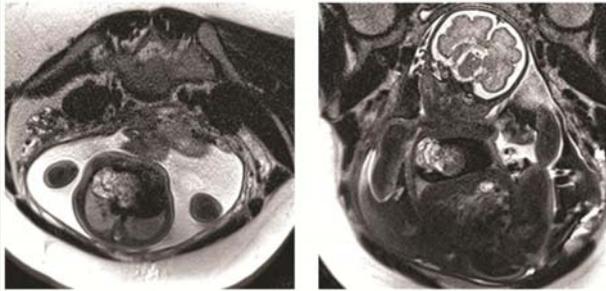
Fetal MR images at 29 weeks gestation. A) axial and B) coronal T2 weighted images oriented to the fetus showing a large T2 hyperintense mass with septations impinging upon the right atrium. The heart appears enlarged. No pleural effusion is identified.
